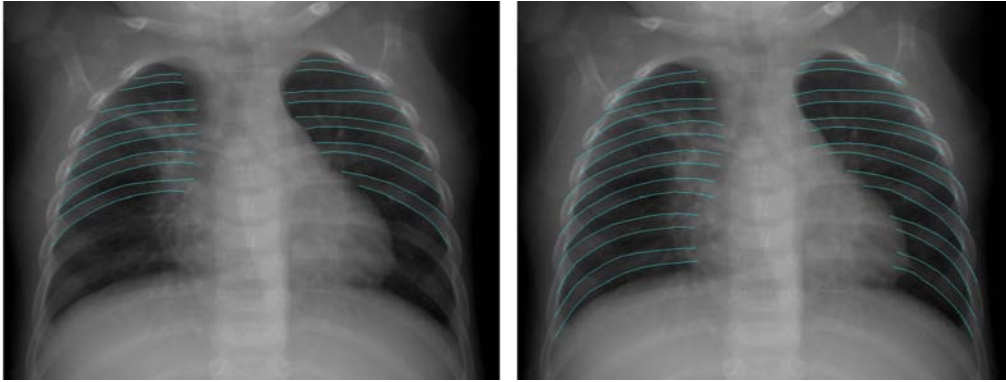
Two manual segmentations of the same radiograph. The left image shows a segmentation of the first five ribs. The right image shows the segmentation of all ribs overlapping the lungs.
